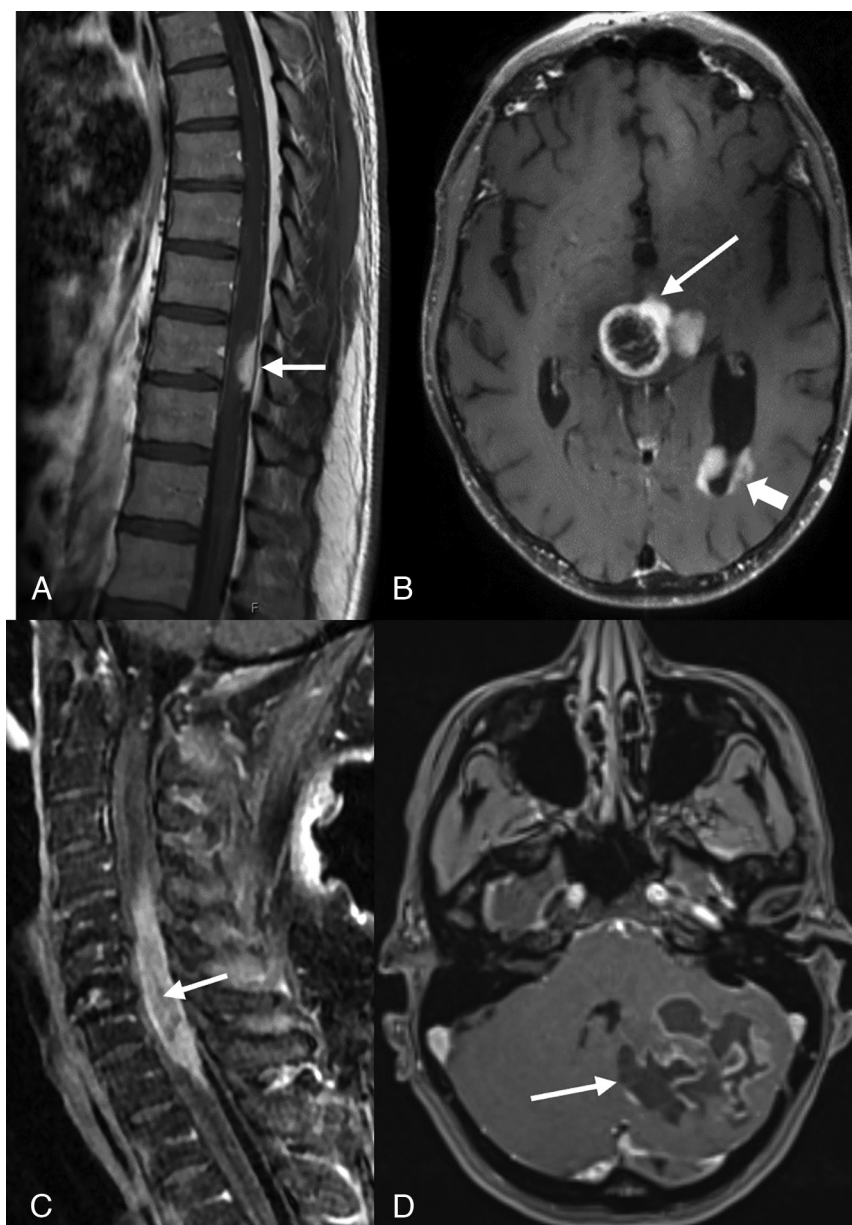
Postcontrast-T1-weighted sagittal (A) image of a 44-year-old man with midback pain shows a well-defined enhancing lesion involving the dorsal aspect of thoracic cord at the T9–T10 level (arrow). Postcontrast T1-weighted axial image in a 42-year-old man (B) shows tumor with peripheral irregular enhancement at the level of thalamus (arrow) with infratentorial pontomesencephalic and cerebellar involvement (not shown) along with diffuse intraventricular tumor seeding (arrowhead). Postcontrast T1-weighted sagittal (C) image of a 74-year-old man with weakness and difficulty walking shows an intramedullary heterogeneously enhancing tumor involving nearly the entire cord C5–T1 (arrow) along with cord expansion. Postcontrast T1-weighted axial (D) image in a 38-year-old man demonstrates a large multicystic lesion with peripheral enhancement in the left cerebellum (arrow).
